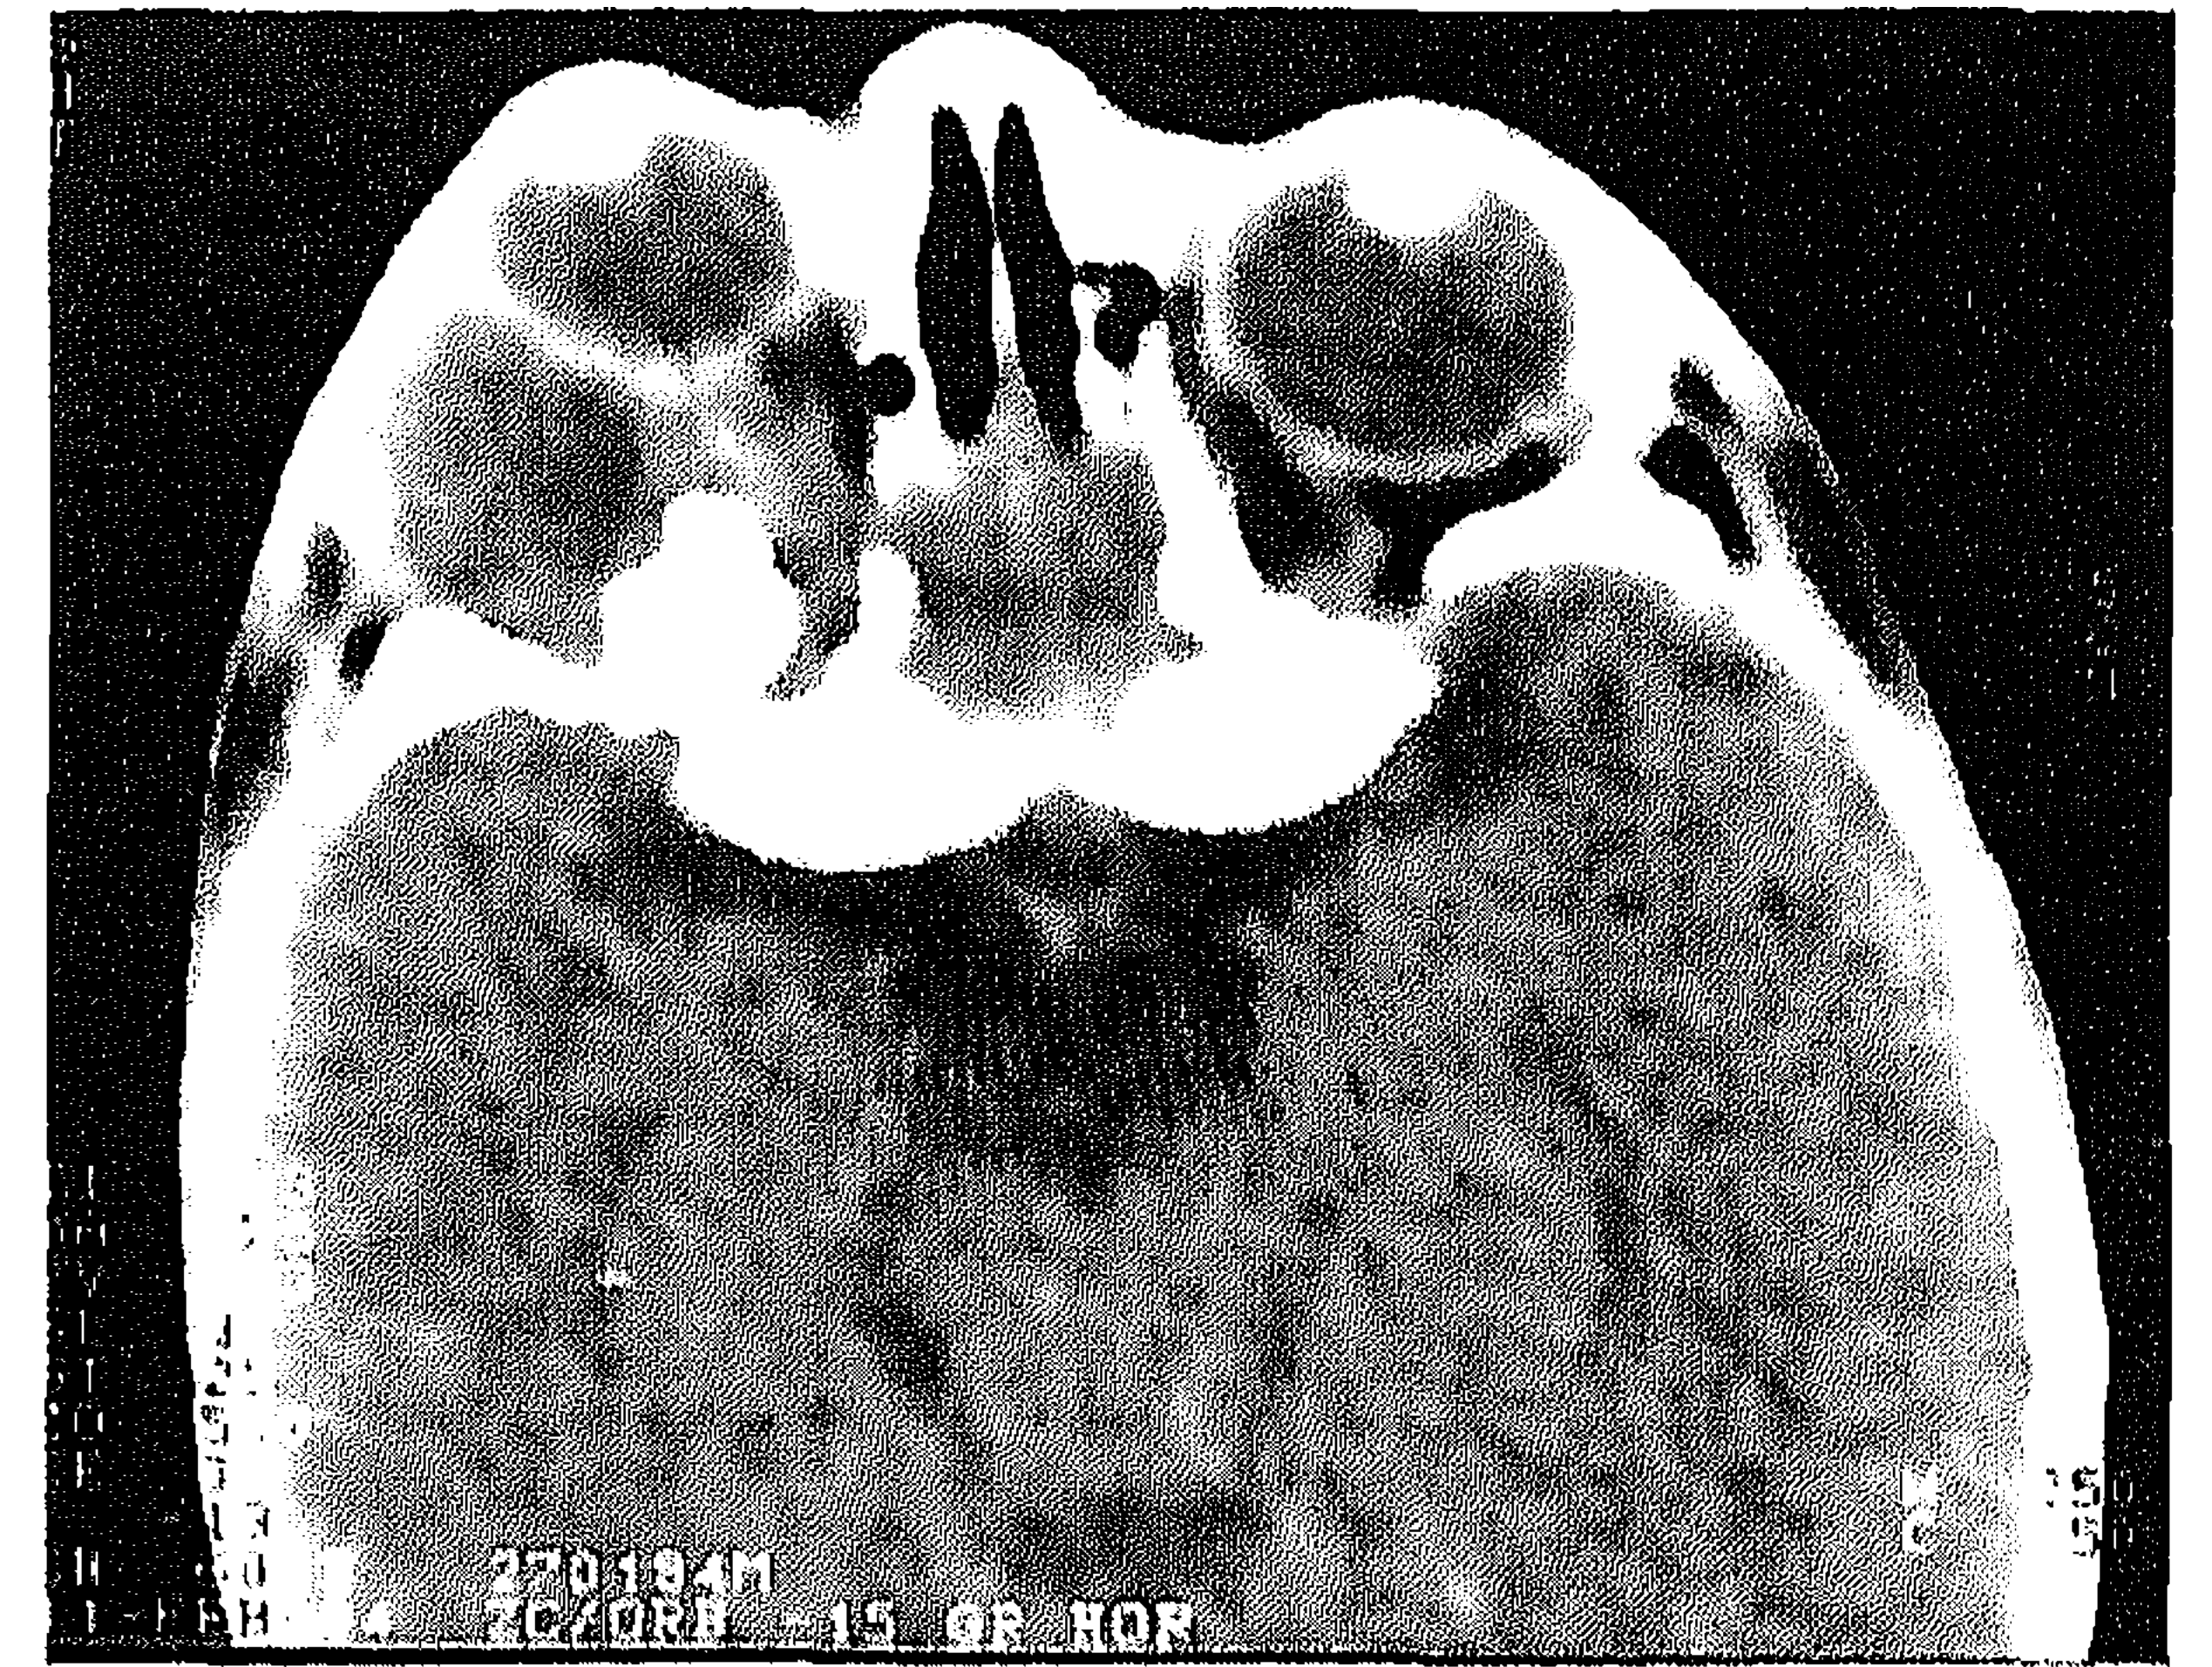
Computed tomogram showing a cystic lesion with apical calcification in the right orbit.
